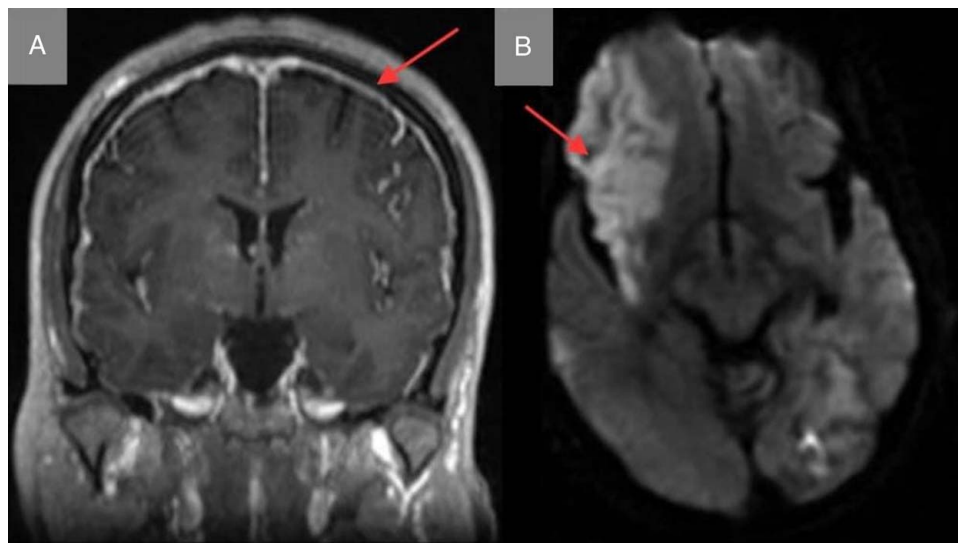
The findings of an MRI scan of the brain showing pachymeningeal enhancement seen along bilateral lateral convexity of the cerebral hemisphere as depicted by the red arrows in (A) and (B).
